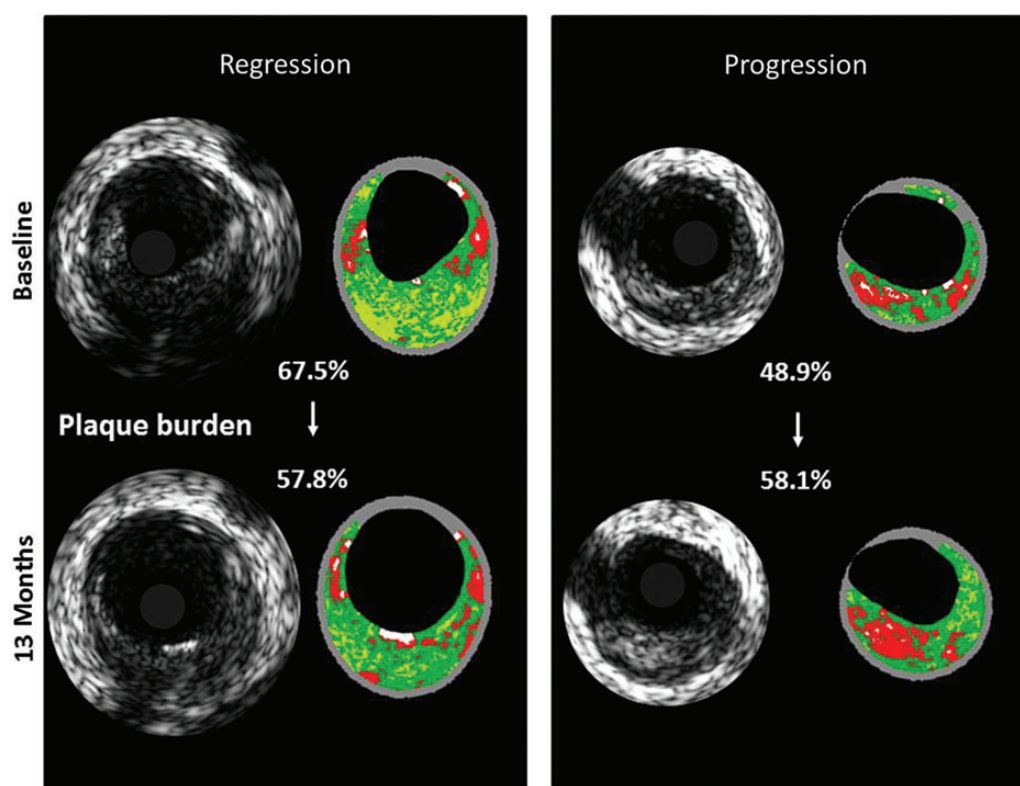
Example of a lesion showing a regression (left panel) and progression (right panel). The left cross section (black and white images) indicates the intravascular ultrasonography greyscale findings and the four coloured cross sections on the right indicate radiofrequency intravascular ultrasonography analysis.
